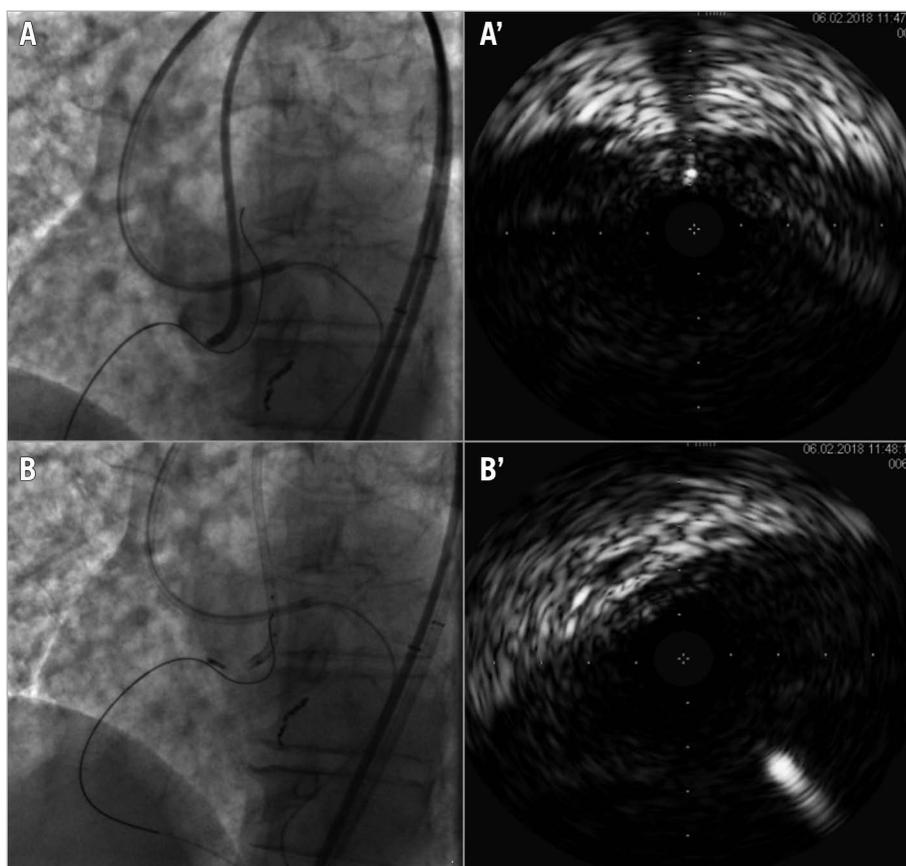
IVUS for ostial RCA re-entry. A, A') ULTIMATEbros 3 guidewire (Asahi Intecc) retrograde crossing in aorta but IVUS shows the wire in the aortic wall. B, B') New attempt of ULTIMATEbros 3 retrograde crossing and IVUS confirmation of a correct position within the aortic lumen. IVUS: intravascular ultrasound; RCA: right coronary artery
